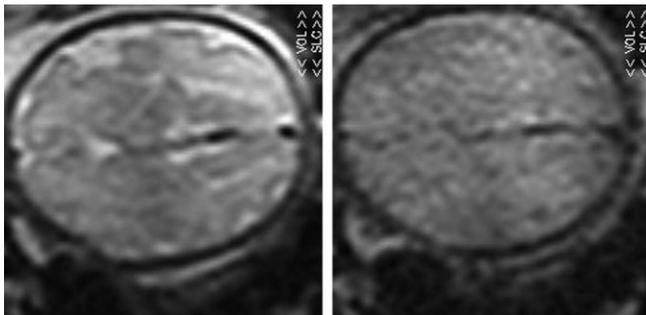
Motion detected in the first and last $b=0$ images. Although the last $b=0$ image is heavily T_1 -weighted, the edge structure is maintained. In this example, it can be seen that the fetus moved in two ways during the DWI exam. A gross movement to the upper direction can be seen in addition to a slight rotation clockwise.
